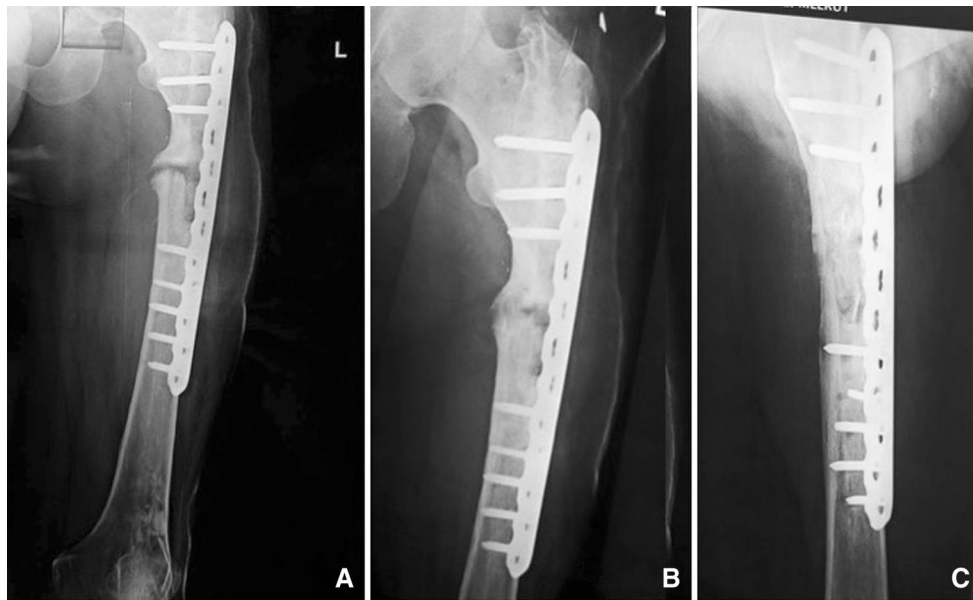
Preoperative radiographs of nonunion proximal femur with locking plate in situ, (a) 12 weeks post-PRP injection radiograph, (b) 16 weeks post-PRP injection radiograph showing solid union (c)
